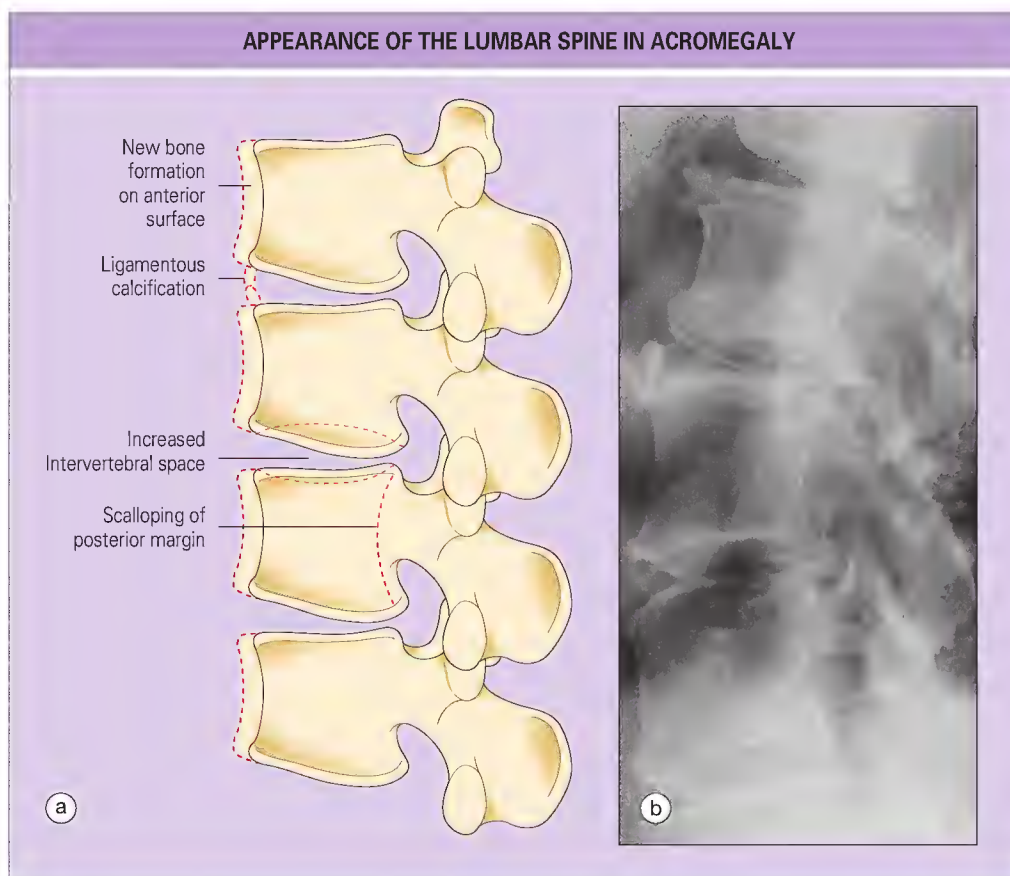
(a) Typical changes include scalloping of the posterior margin of the vertebrae, new bone formation on the anterior surfaces, and increased intervertebral space. (b) A radiograph of the lumbar spine shows the decrease in disk height because of late degenerative disease.
